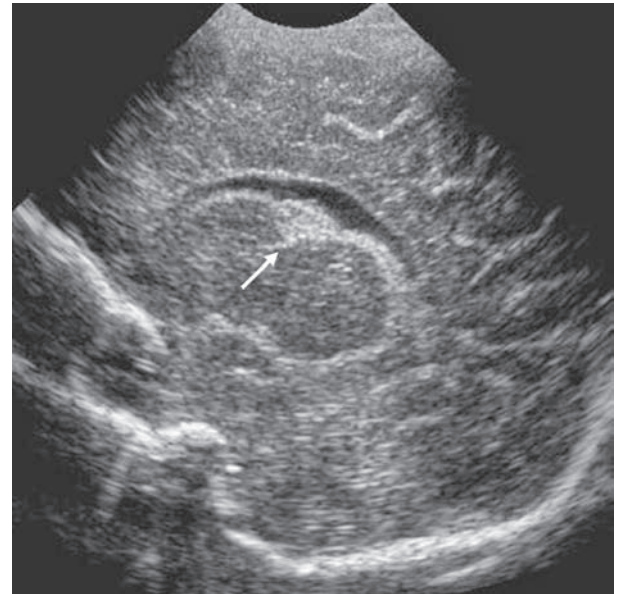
Grade 1 haemorrhage. Left parasagittal ultrasound scan shows a focus of increased echogenicity in the caudothalamic groove in keeping with subependymal haemorrhage (arrow)
